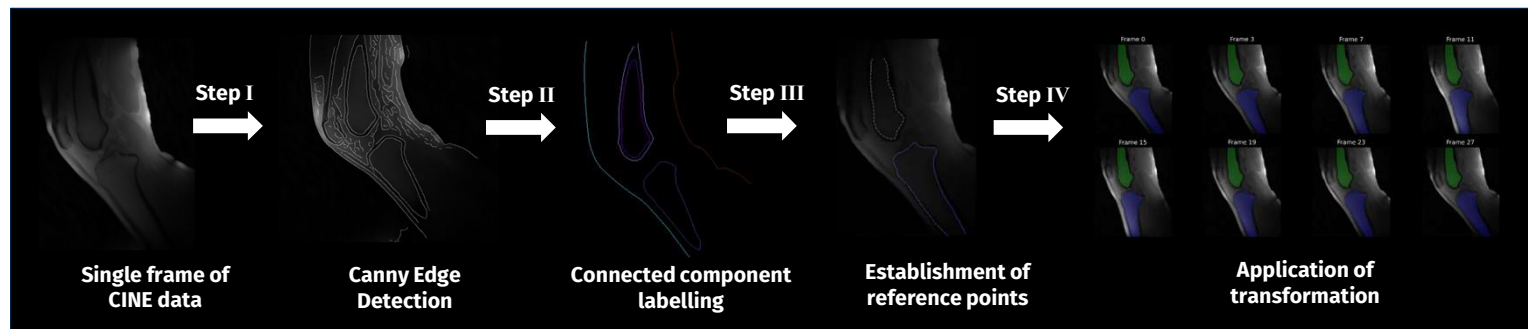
CINE MRI of Knee Joint During Flexion-Extension Cycle
